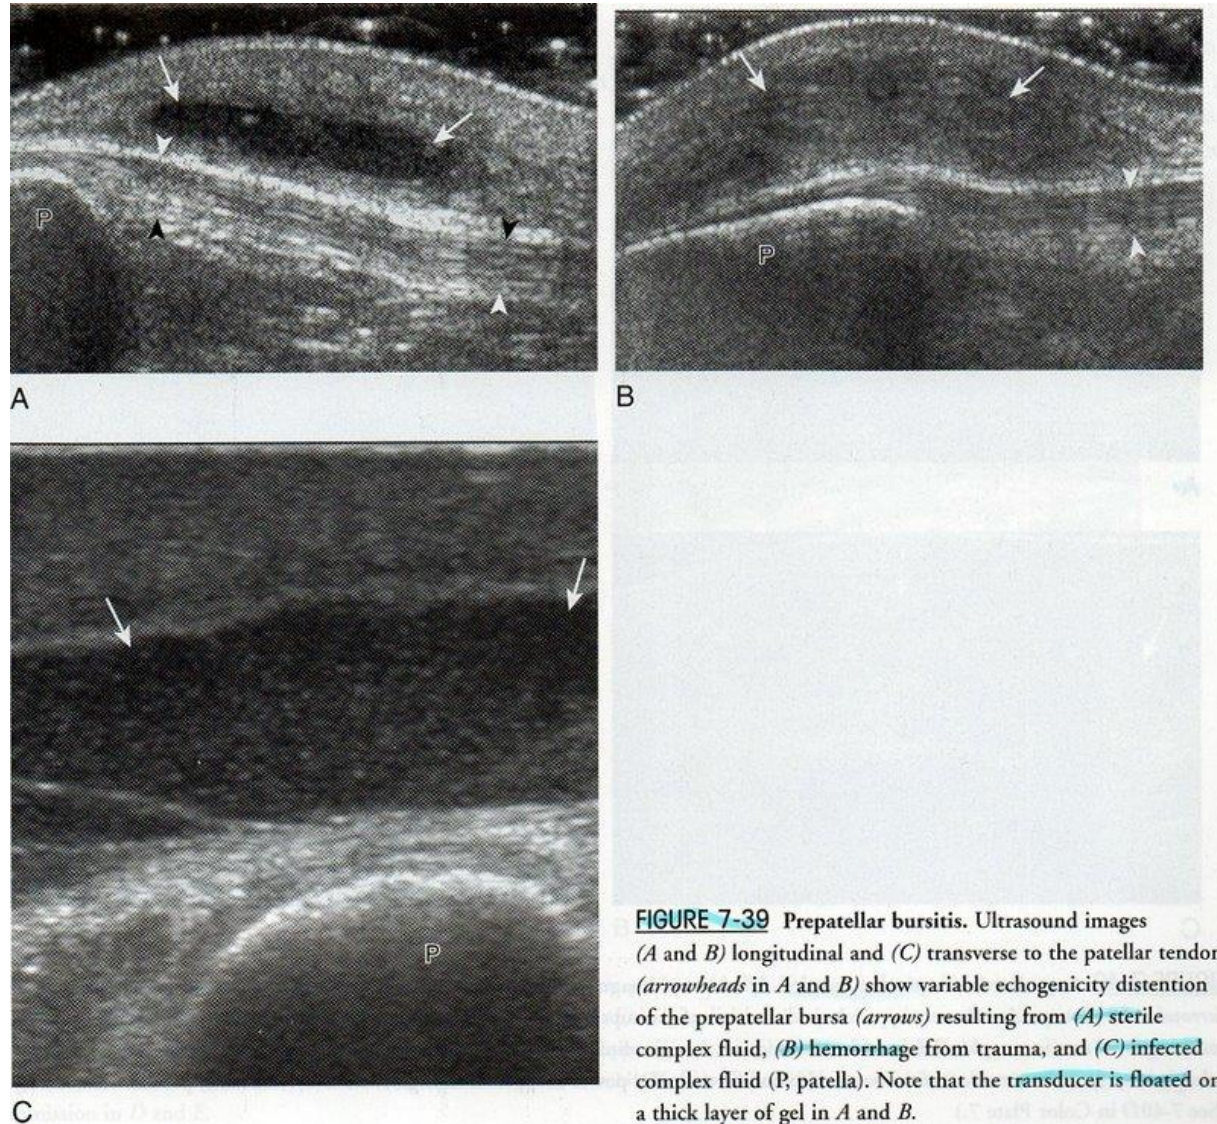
Prepatellar bursitis. Ultrasound images (A and B) longitudinal and (C) transverse to the patellar tendon (arrowheads in A and B) show variable echogenicity distention of the prepatellar bursa (arrows) resulting from (A) sterile complex fluid, (B) hemorrhage from trauma, and (C) infected complex fluid (P, patella). Note that the transducer is floated on a thick layer of gel in A and B.
